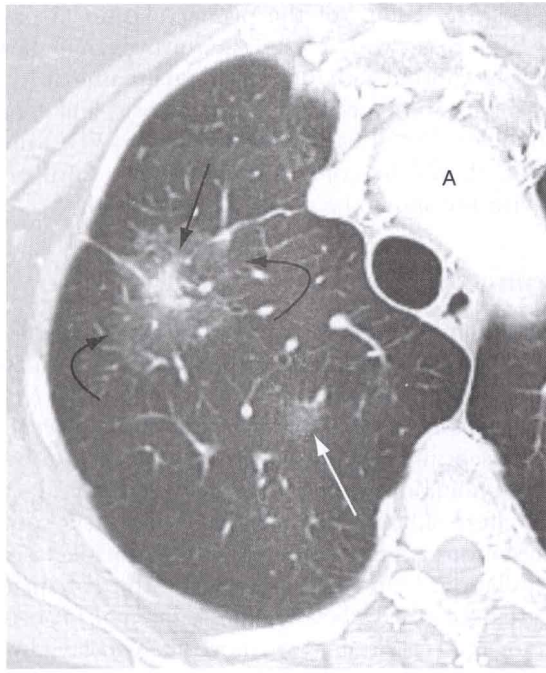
Multifocal bronchioloalveolar cell carcinoma in a 68-year-old woman. Contrast-enhanced chest CT scan at the level of the transverse aorta (A) shows one focus of her cancer to be a nodule with a ground-glass appearance (white arrow) and another focus as a mass of mixed attenuation: ground-glass opacity (curved arrows) with a solid center (black straight arrow).
